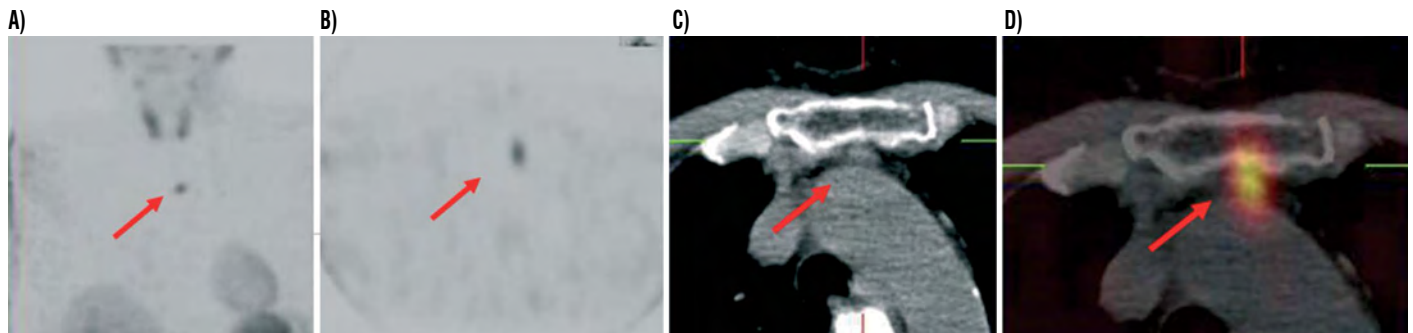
^{99m}Tc sestamibi SPECT/CT in ectopic parathyroid adenoma retrosternally. (arrow). Accurate localisation is necessary for surgery (A) MIBI, (B) SPECT, (C) CT, (D) Fusion image
